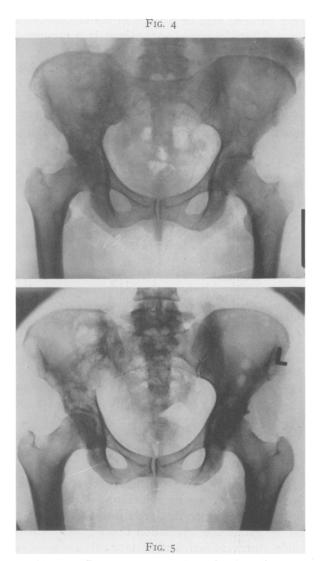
Roentgenogram taken October 6, 1944, showing multiple osteolytic metastases.
